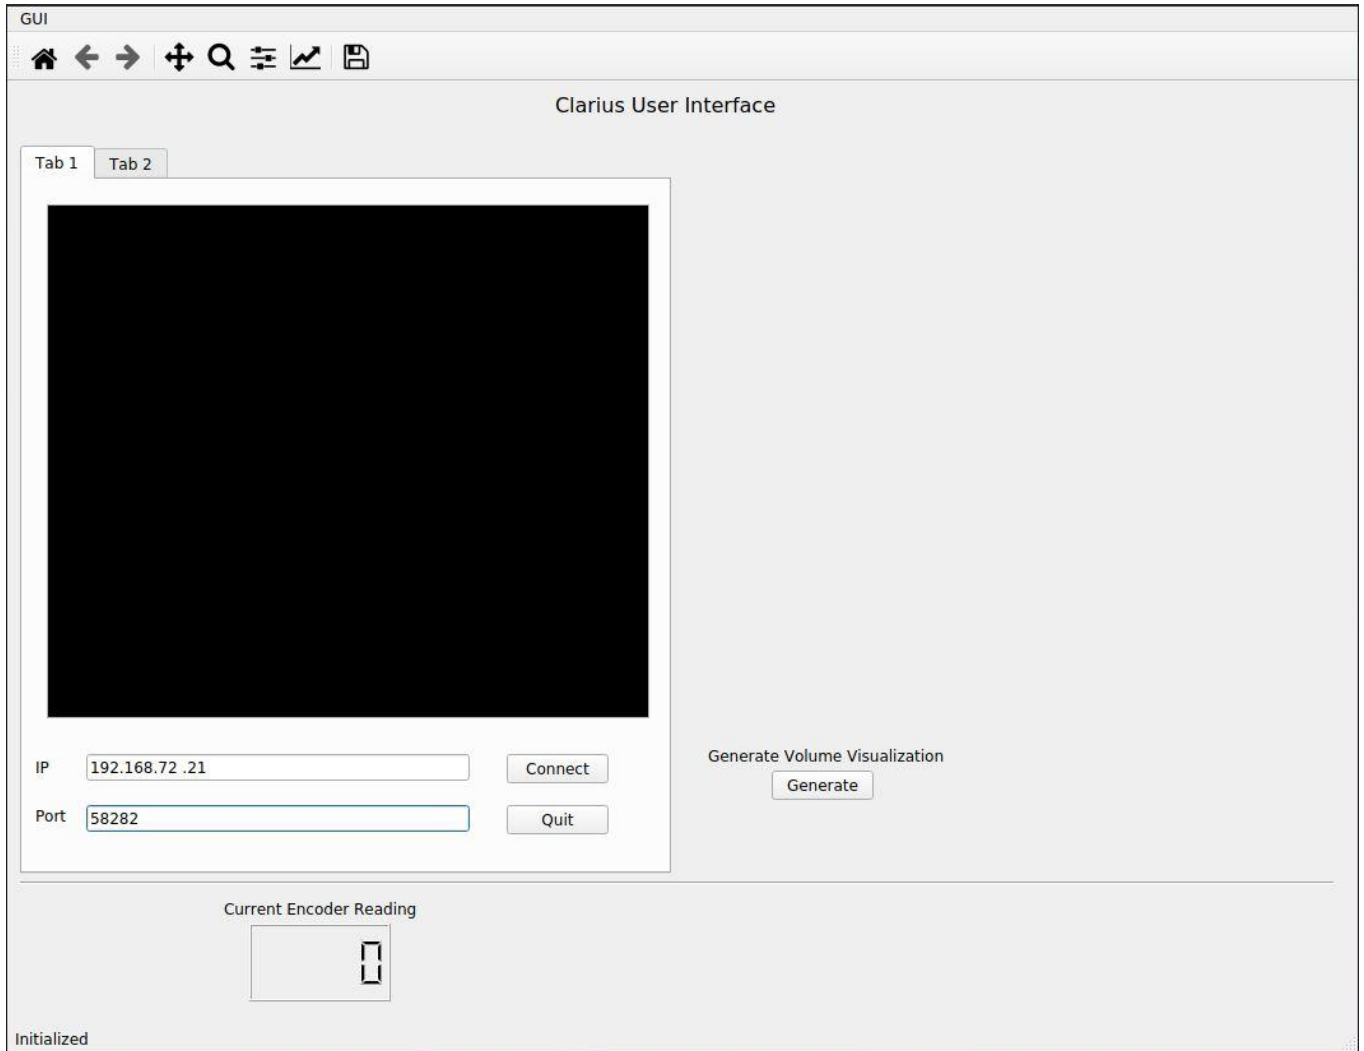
Stream Live Ultrasound Images with GUI
